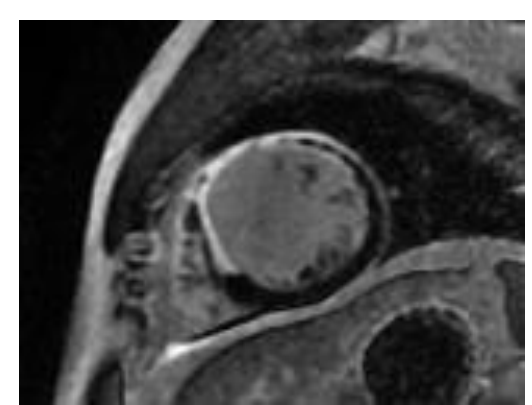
Assessment of the infarct gray zone: Short-axis contrast-enhanced MRI of a patient with a previous MI. A, Endocardial (red) and epicardial (green) borders were outlined manually. Subsequently, the maximum signal intensity (SI) within the infarct region was determined. B, The infarct core was defined as myocardium with SI $\geq 50\%$ of the maximum SI (red area). C, The infarct gray zone was defined as myocardium with SI $\geq 35\%$ but with SI $< 50\%$ of the maximum SI (yellow area). Summation of the infarct core and infarct gray zone yielded the total infarct size (red plus yellow area).
